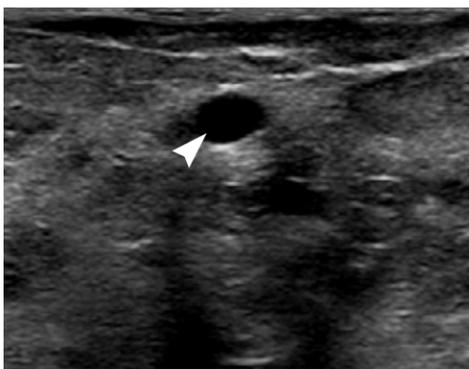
Simple cyst on breast ultrasound
